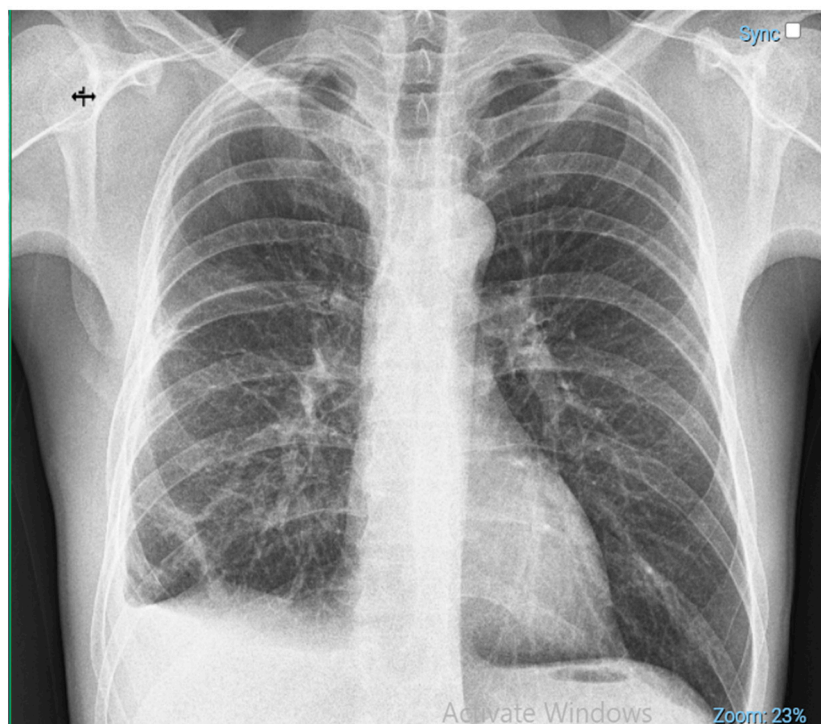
Chest X-ray 1 week post-operatively. Small amount of pleural fluid at the level of the right costo-diaphragmatic sinus; normal expansion of the right lung.
